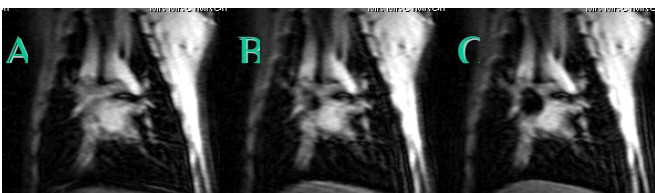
Near-real-time (~1 fps) coronal GRE MRI Images of laser-balloon advancement (A), deployment (B), and dilation (C). Note the large susceptibility artifact due to the non-MRI-compatible sheath in lower image. D₂O-filled balloon provides a nice passive marker. TR/TE/ θ =35.7ms/2.2ms/20deg, 24x24 cm FOV, 128x64, 6.0 mm slices.
